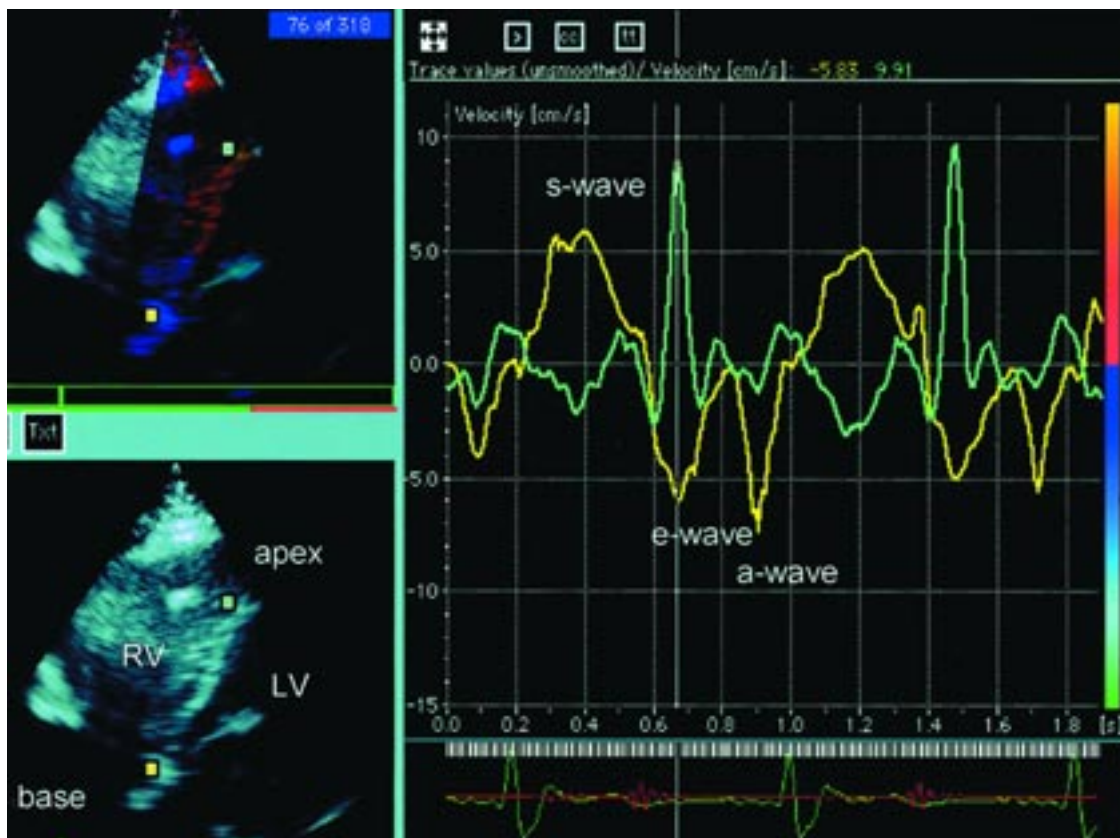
A tissue Doppler echocardiographic study shows a change of color from blue to red in the myocardial septum as evidence of iron loading. The reversals of the s and e waves at the apex denote systolic and diastolic wall motion abnormalities. This may occur even in patients with thalassemia whose ejection fractions are within the normal range.
